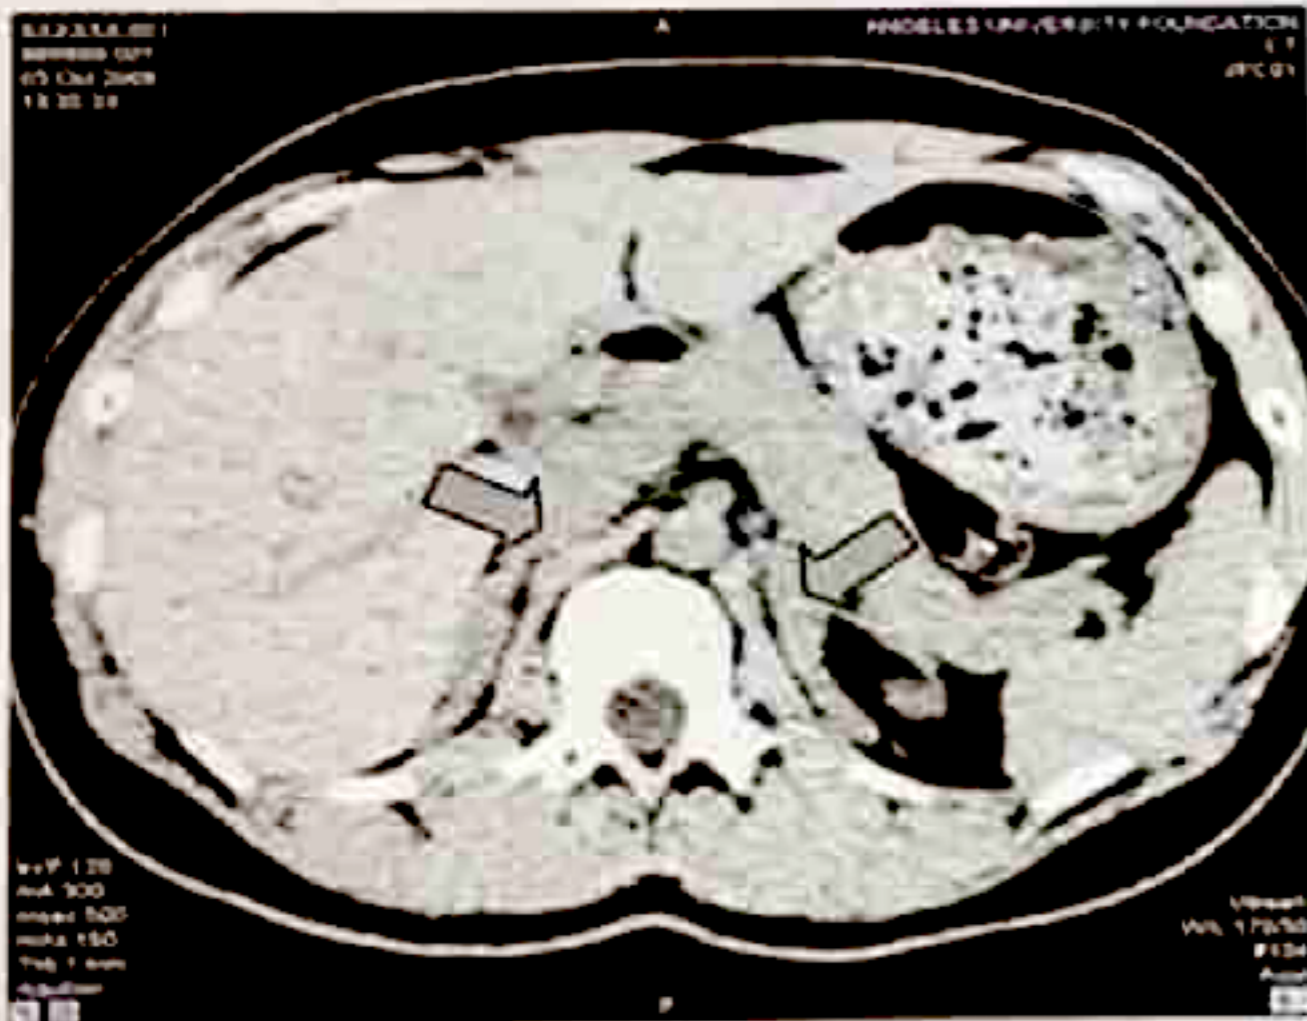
CT scan-Bilateral adrenal hyperplasia.
